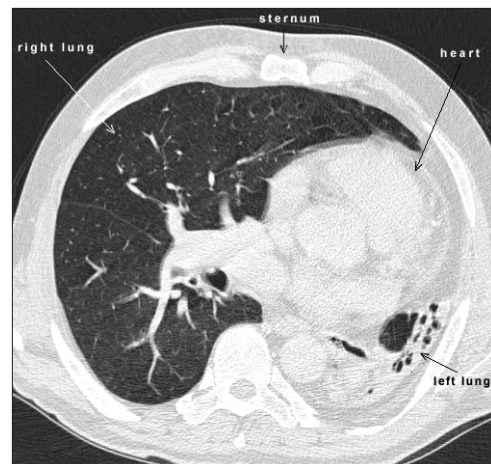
Thoracic computed tomography demonstrating hyperlucency, reduced volume, diminished vascularity in left lung in a patient with Swyer-James syndrome
